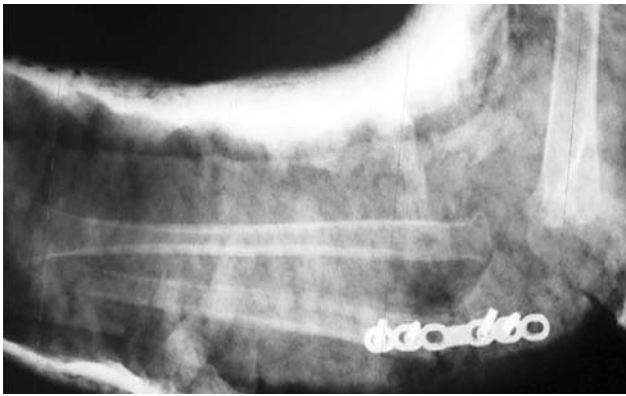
Post-operative lateral roentgenography of case 1(early)
